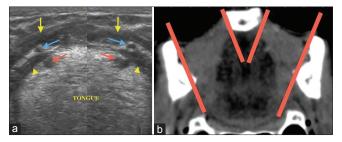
(a) Split/dual coronal Sections in submental location using linear transducer, demonstrating sonoanatomy of step 2b structures of either side (posterior floor of mouth). (b) Corresponding computed tomographic section (red lines – representing limit of ultrasound scan extent on either side) yellow arrows, mylohyoid muscle; yellow arrowhead, hyoglossus muscle; blue arrow, submandibular gland duct; red arrow, lingual artery
